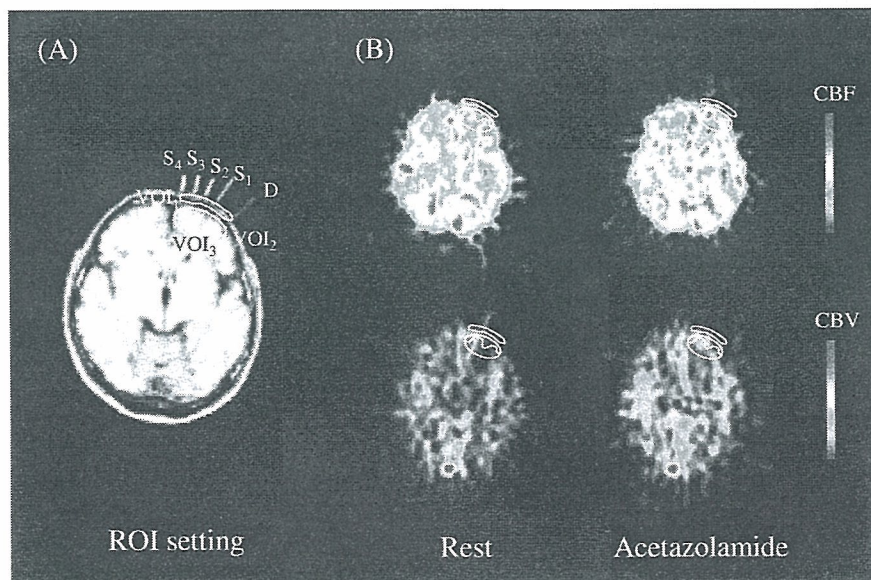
Fiber and ROI positions on MRI image and PET images. (A) Fiber markers appear on left forehead. S_{1-4} and D are corresponding to irradiation fibers and a detection fiber, respectively. Optode spacings of S_1 - D : 2 cm, S_2 - D : 3 cm, S_3 - D : 4 cm, S_4 - D : 5 cm were set. The four PET VOIs were set as follows. VOI_1 : extracerebral tissue, VOI_2 : gray matter region, VOI_3 : gray matter and white matter regions. (B) Images of typical measurements (41 years old; male) of PET CBF (upper) and PET CBV (lower) in the resting (left) and loading (right) state.
